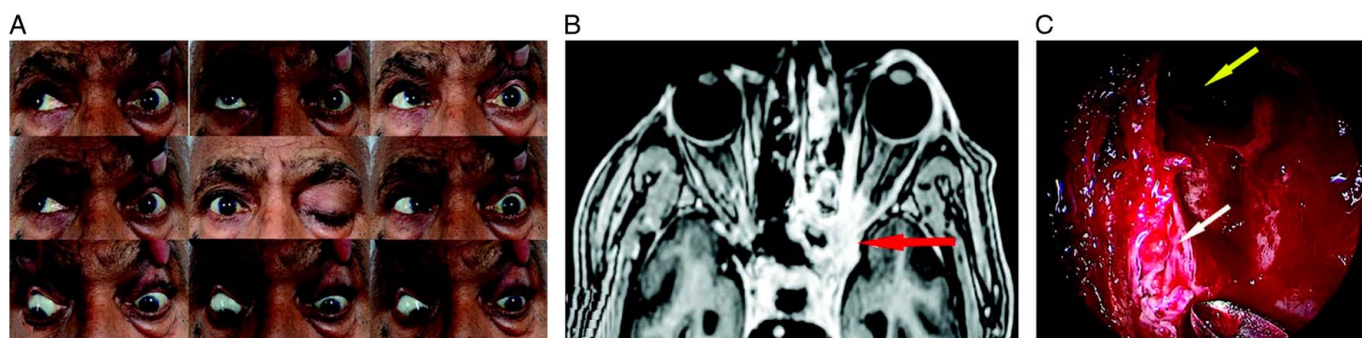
Stage 4a ROCM (A) Clinical photograph showing restriction of ocular movements in all gazes in the left eye. B, Axial MRI (T1) of the orbit and brain showing diffuse orbital involvement along with focal cavernous sinus involvement (red arrow). C, Endoscopy picture showing eroded left cribriform plate (white arrow) with dural defect (yellow arrow). Endoscopy image provided by Sandeep Karmarkar [reproduced with permission from Sen M, Honavar SG, Bansal R, Sengupta S, Rao R, Kim U, Sharma M, Sachdev M, Grover AK, Surve A, Budharapu A. Epidemiology, clinical profile, management, and outcome of COVID-19-associated ROCM in 2826 patients in India—Collaborative OPAL-IJO Study on Mucormycosis in COVID-19 (COSMIC), Report 1. Indian Journal of Ophthalmology. 2021 Jul;69(7):1670.]¹¹³ COVID-19 indicates coronavirus disease 2019; ROCM, rhino-orbital-cerebral mucormycosis.
